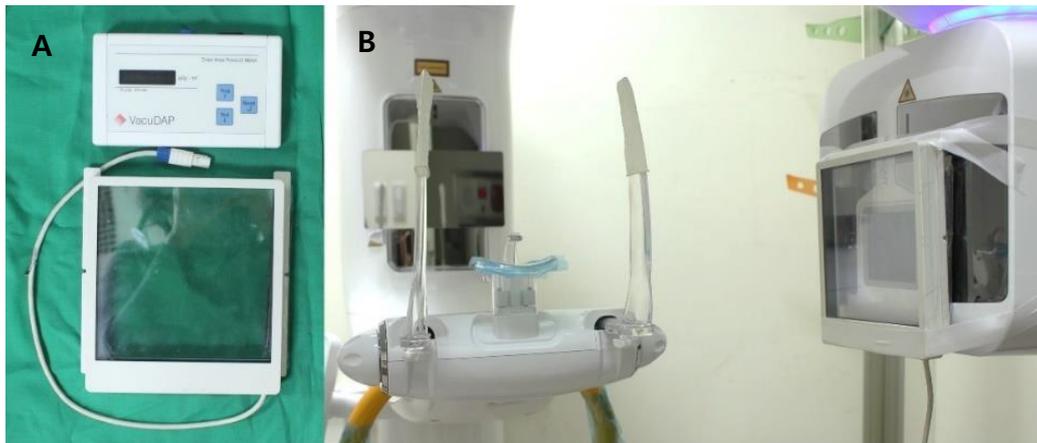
A, DAP meter (VacuDAP™; VacuTec Meßtechnik GmbH, Dresden, Germany); B, DAP measurement in CBCT unit.
